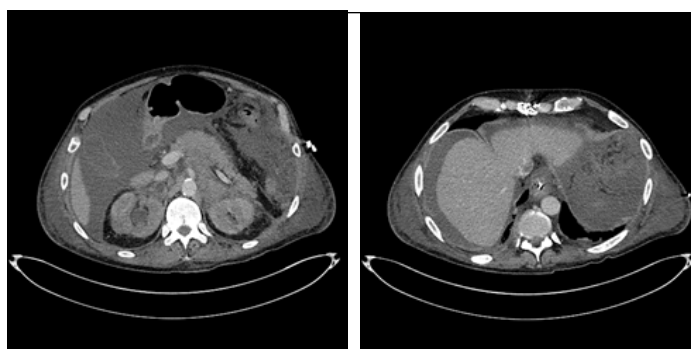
CT scan of the thorax, abdomen and pelvis showing extensive retroperitoneal soft tissue which encased the renal collecting system causing obstruction. Extensive omental and mesenteric infiltration with a large volume of free fluid.
